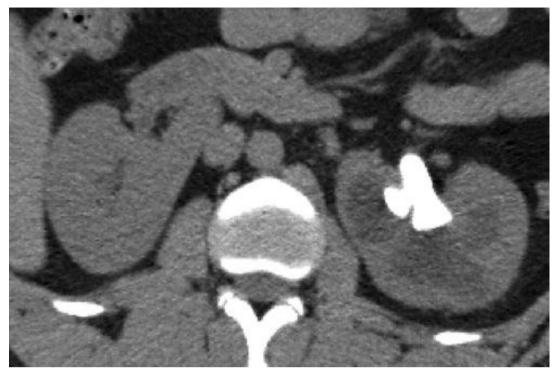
Unenhanced CT examination shows left hydronephrosis related to staghorn calculus.
